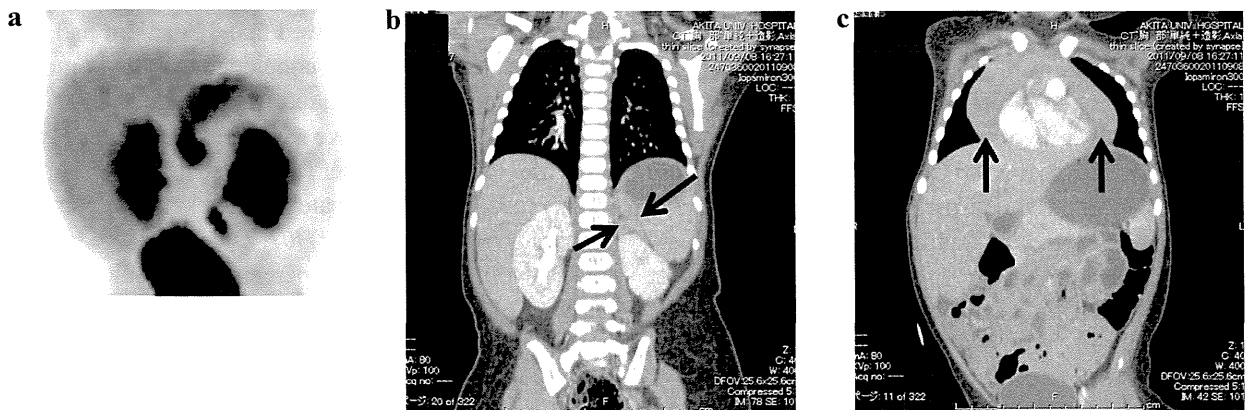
(a) Representative patterns of 18 F]DOPA uptake. Maximum intensity projection obtained 30 min after injection. Multifocal or diffuse uptake in the head and body of the pancreas. (b) CT with contrast showed a mass adjacent to the upper segment of the left kidney (arrows). (c) CT with contrast showed an enlarged mass occupying the anterior mediastinum (arrows), indicating thymic hyperplasia.
